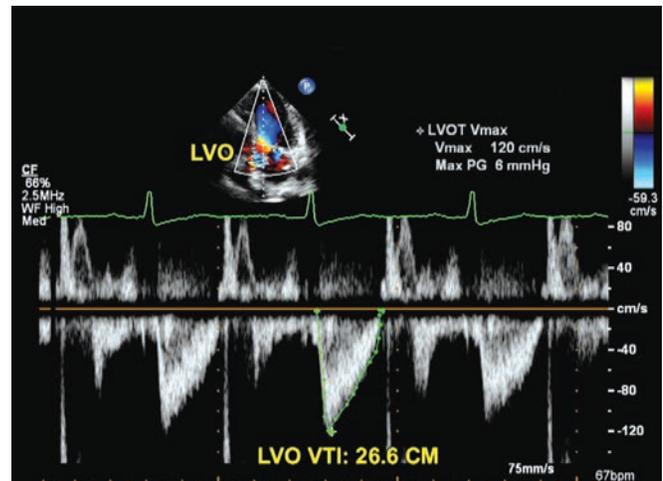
Apical five chamber view. Pulsed Doppler examination of left ventricular outflow tract (LVOT). VTI = Velocity time integral.
